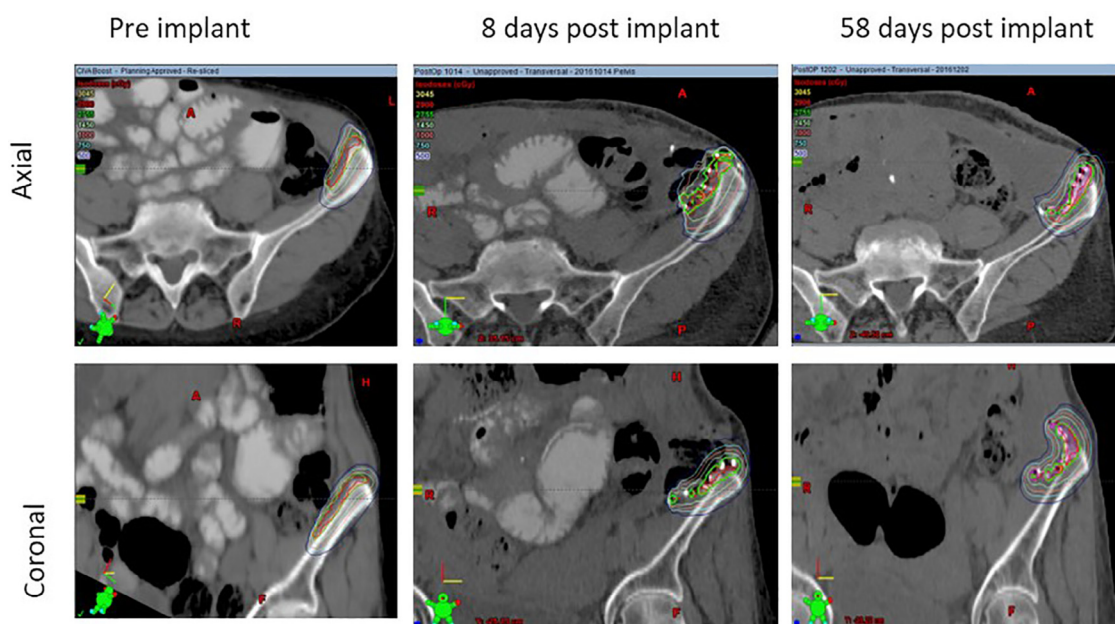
Pre- and postimplant computed tomography studies for patient 2. The isodoses shown are 5.0 Gy (blue), 7.5 Gy (cyan), 10.0 Gy (pink), 14.5 Gy (light green), 27.55 Gy (green), 29.0 Gy (red), and 30.45 Gy (yellow).
